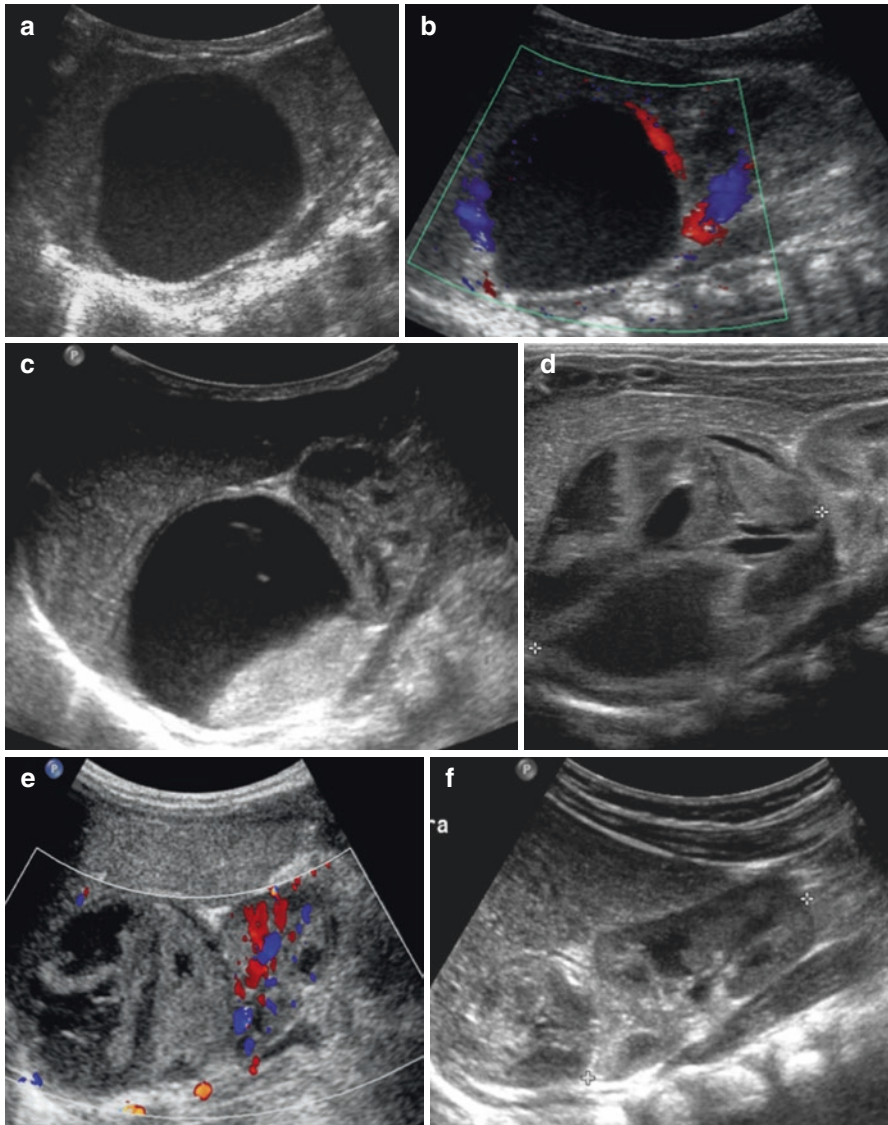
A 6-day-old newborn with detection on ultrasonography of a right cystic suprarenal mass (a), associated with slightly increased excretion of urinary catecholamines. Vascularization was only peripheral on colour Doppler (b). After 2 weeks, the size of the mass appeared unchanged, whereas a large amount of debris was present (c). After 6 weeks, the mass appeared partially solid (d), with no evidence of vascularization on colour Doppler (e). At 23 weeks of age, the mass appeared mostly solid and slightly reduced in size (f). At 31 weeks of age, the mass was smaller and hyperechoic with tiny calcifications (g). Finally, at 45 weeks of age, CT contrast-enhanced coronal image showed an almost complete regression of the mass (h). These findings and their evolution show the spontaneous regression of a neonatal adrenal neuroblastoma
